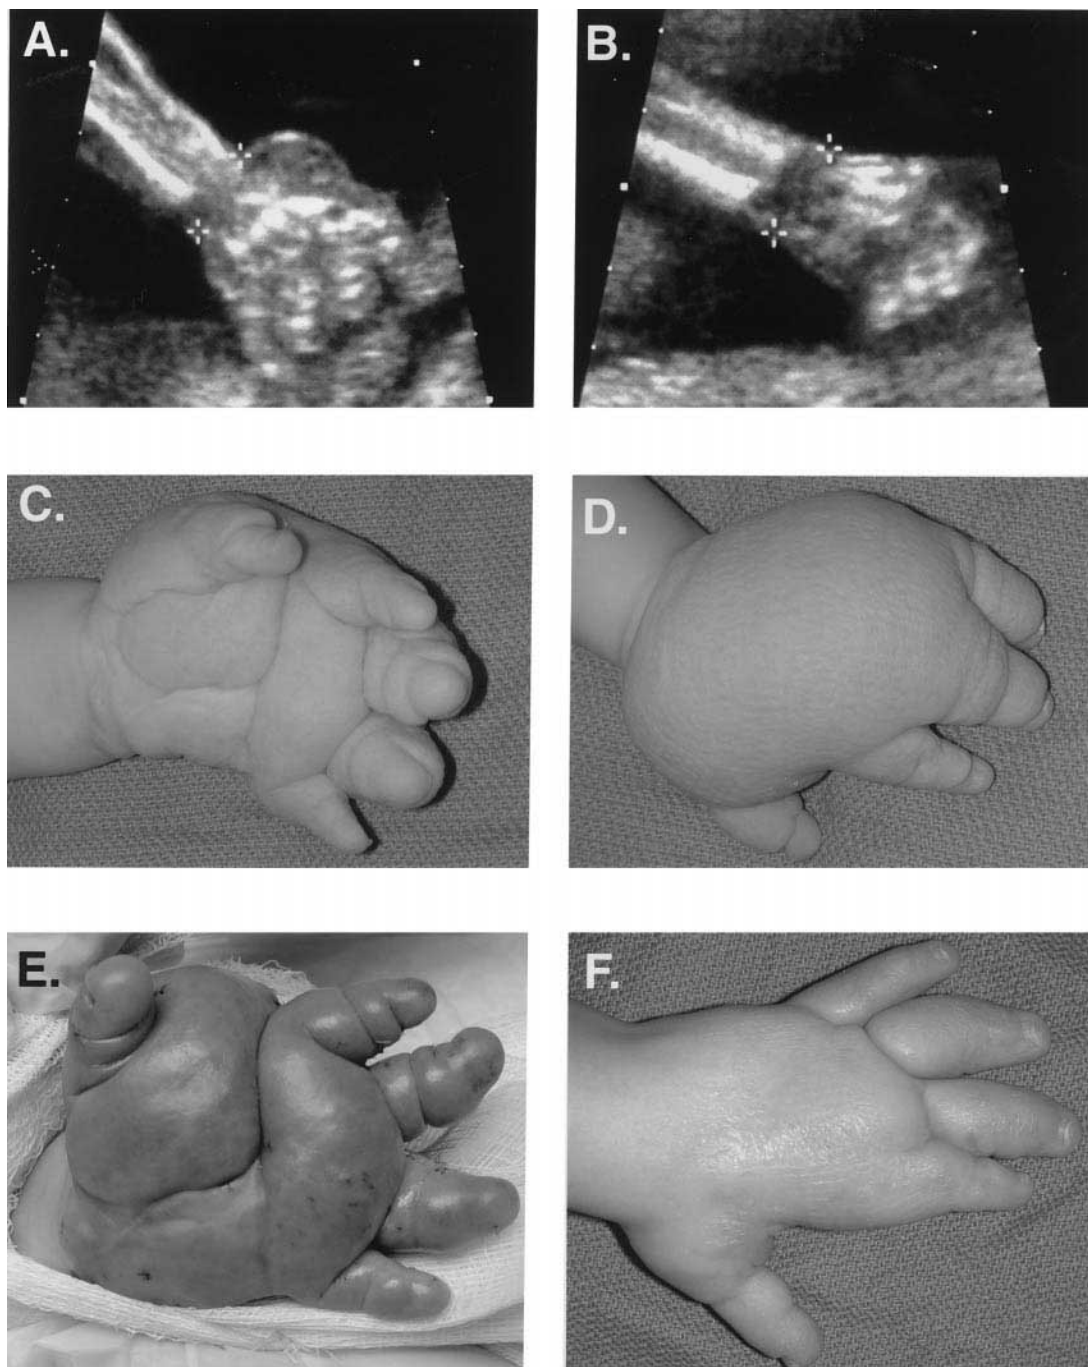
Complication secondary to a lymphatic malformation of the hand prenatally diagnosed as “amniotic band syndrome.” (A) Fetal ultrasonogram of left hand at 22 weeks’ gestation, compared with right hand (B). Hand at 4 months of age—volar (C) and dorsal (D) views. Scar from laser surgery of the fetus can be appreciated on volar surface of the wrist in (C). (E) Postoperative venous congestion after dorsal debulking. (F) Appearance of hand 3 months after second staged resection.
